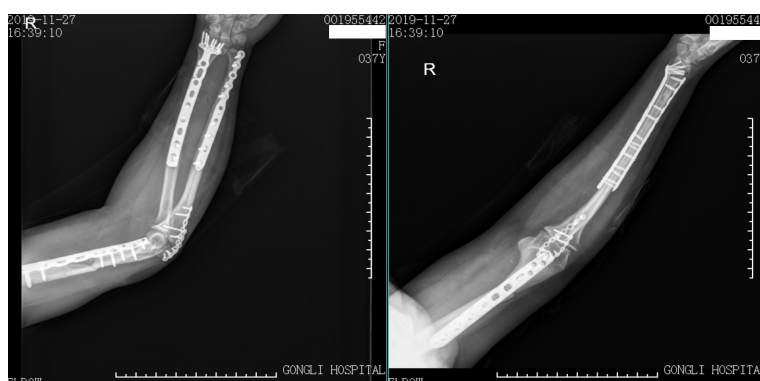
X-ray images of the patient at the 7 mo follow-up.
